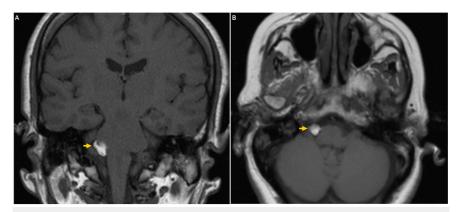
A T1-weighted MRI indicating a right-sided CPA lipoma
